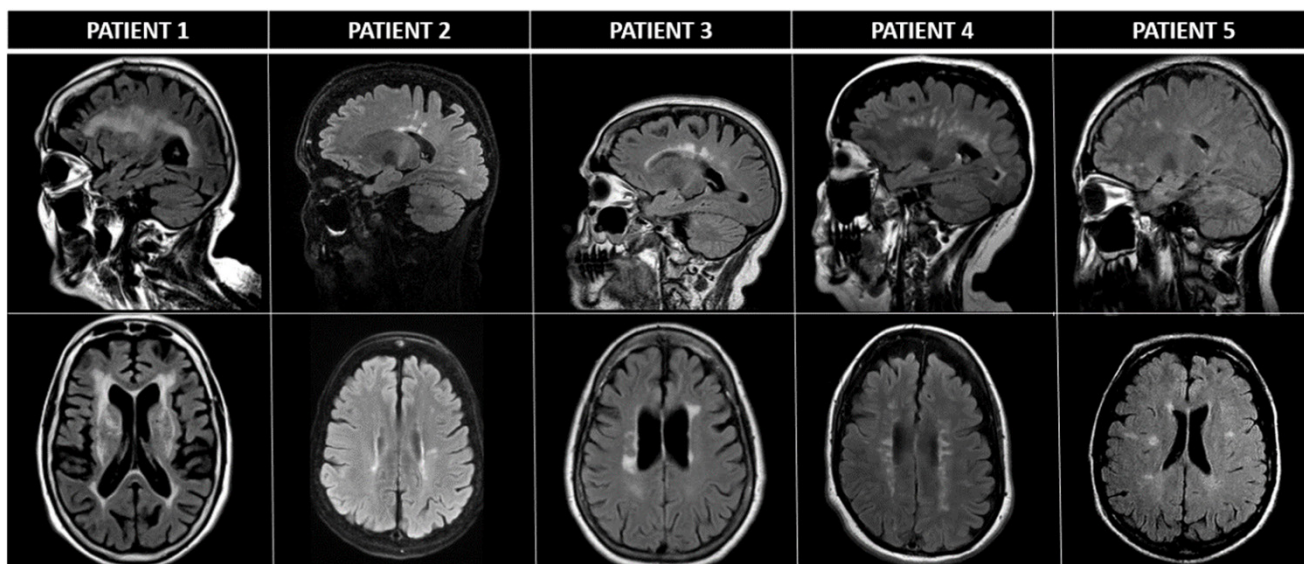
MRI brain imaging demonstrating demyelinating white matter lesions for Patients 1 through 5. Sagittal FLAIR sequences are displayed above their corresponding axial FLAIR images.
